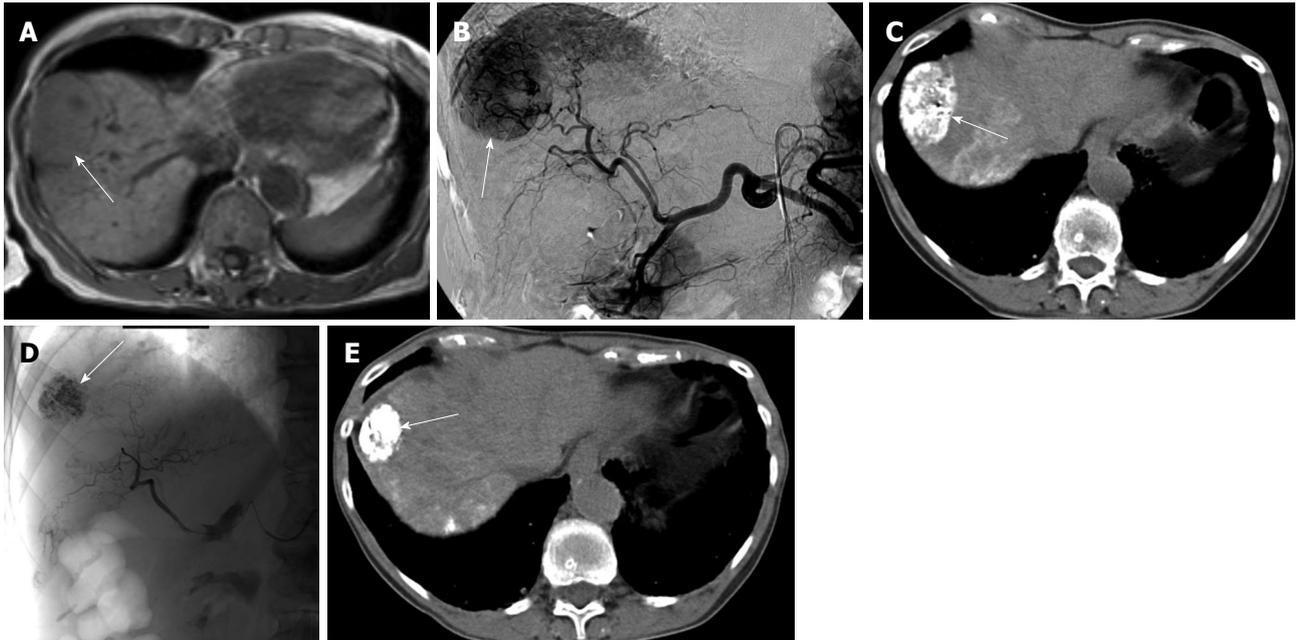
A 76-year-old female patient, hepatitis C virus liver cirrhosis. A: Axial magnetic resonance imaging (MRI) T1 WI showing an isointense subcapsular hepatocellular carcinoma at segment 8 (white arrow); B: Digital subtraction angiography before the 1st transarterial chemoembolization (TACE) showing a large tumor blush at segment 8 (white arrow); C: Computed tomography (CT) after the first embolization showing dense Lipiodol uptake by the tumor (white arrow); D: Hepatic arteriography after the 5th TACE session showing occluded feeding arteries and Lipiodol concentration within the tumor (white arrow); E: CT after the last TACE session showing reduction of the tumor size (> 50%) by MRI volumetry (white arrow).
